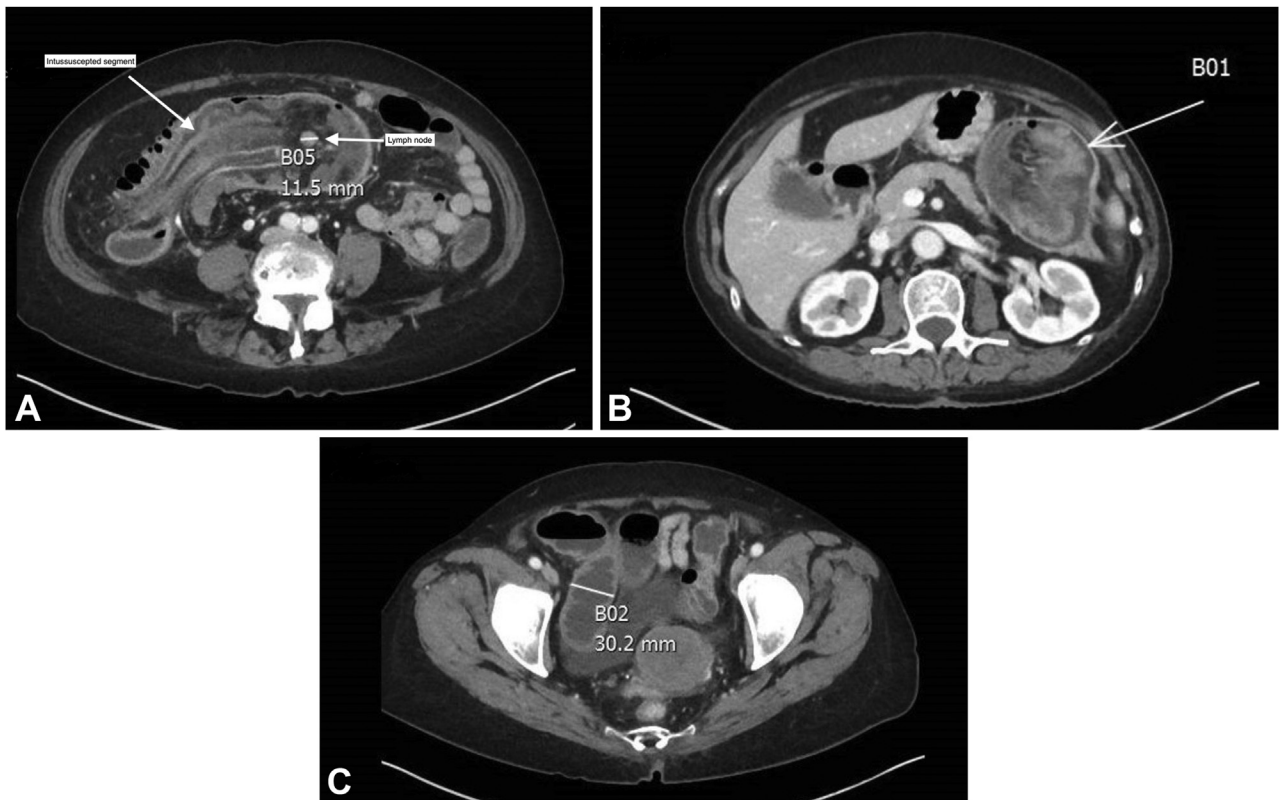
A, A 1.2-cm lymph node at the proximal end of the intussuscepted loop. B, A cecal mass concerning for malignancy can be seen protruding distally up to the splenic flexure. C, A CT scan demonstrating mildly dilated loops of distal small bowel measuring 3.0 cm.
